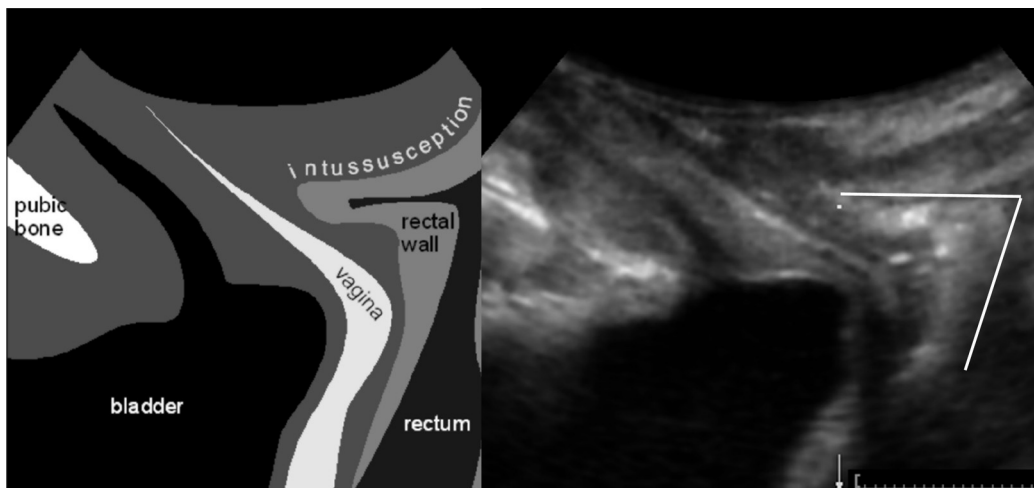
Anal intussusception shown as on translabial ultrasound.
